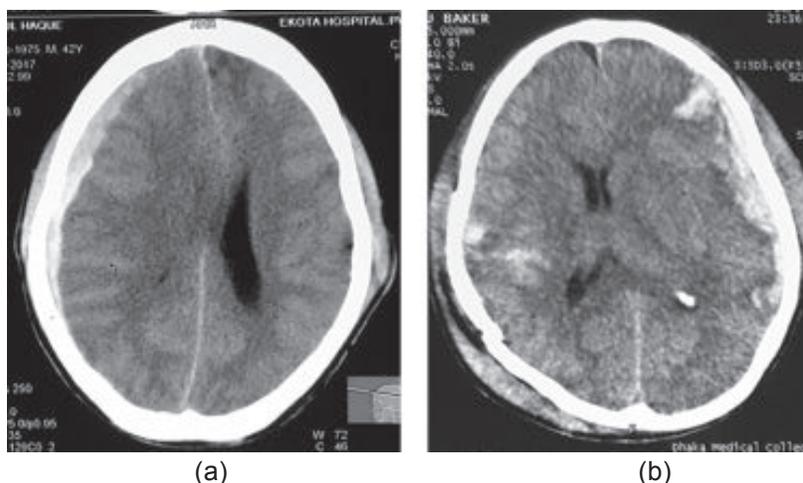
CT Scan of the brain showing acute subdural haematoma without underlying brain injury (a) and with underlying brain injury (b).
